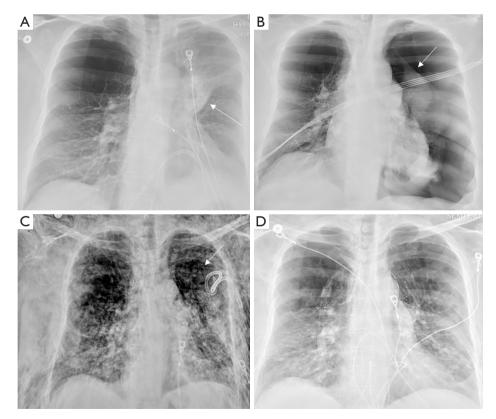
Case of BLVR resulting in pneumothorax. (A) Chest X-ray with left upper lobe atelectasis (arrow) after BLVR. (B) Chest X-ray with left-sided pneumothorax (arrow) 7 days after BLVR. (C) Chest X-ray demonstrating severe subcutaneous emphysema with pneumothorax (arrow) after BLVR with chest tube in place and persistent air leak. (D) Chest X-ray after all valves removed with resolution of pneumothorax and subcutaneous emphysema. BLVR, bronchoscopic lung volume reduction.
